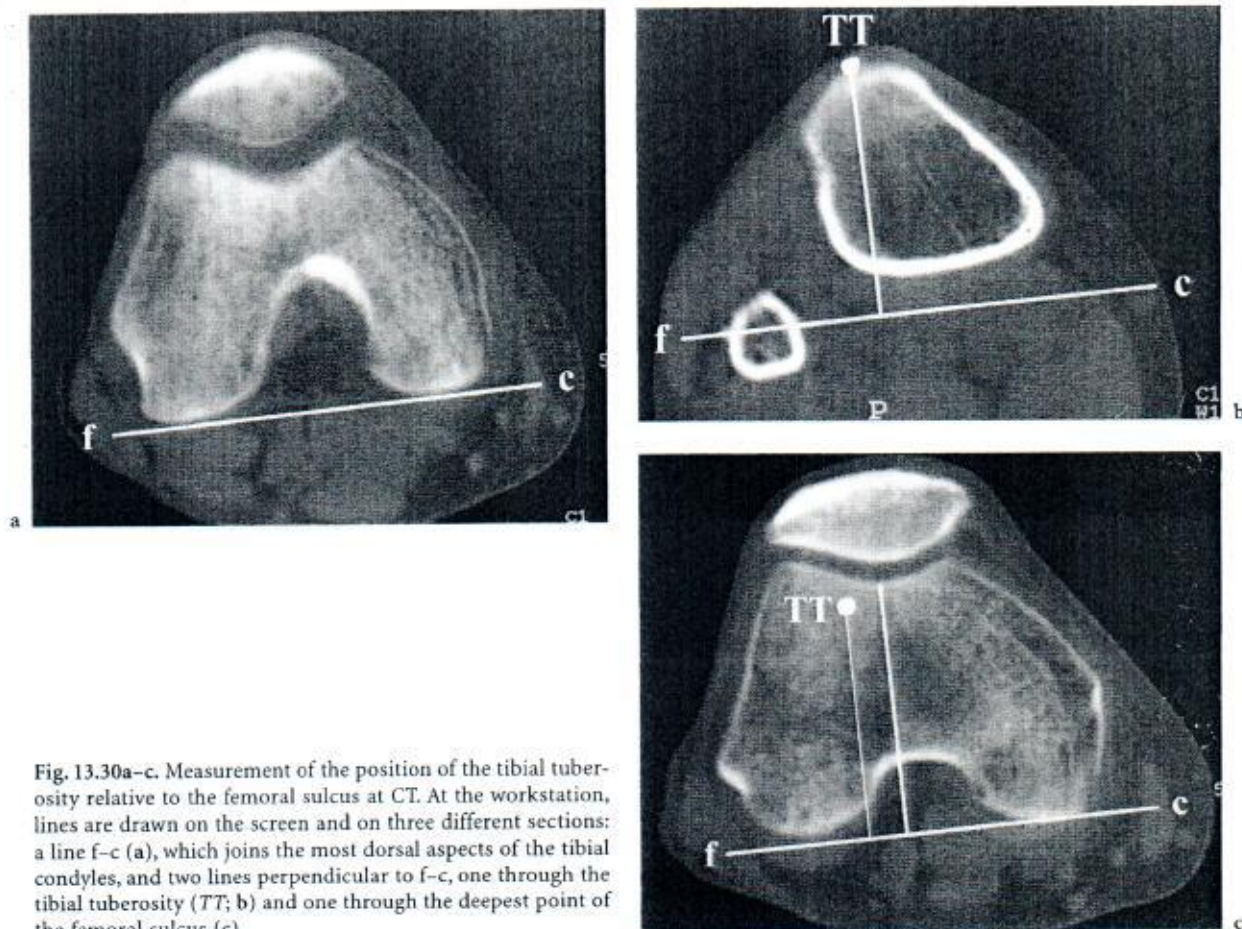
Measurement of the position of the tibial tuberosity relative to the femoral sulcus at CT. At the workstation, lines are drawn on the screen and on three different sections: a line f-c (a), which joins the most dorsal aspects of the tibial condyles, and two lines perpendicular to f-c, one through the tibial tuberosity (TT; b) and one through the deepest point of the femoral sulcus (c)
